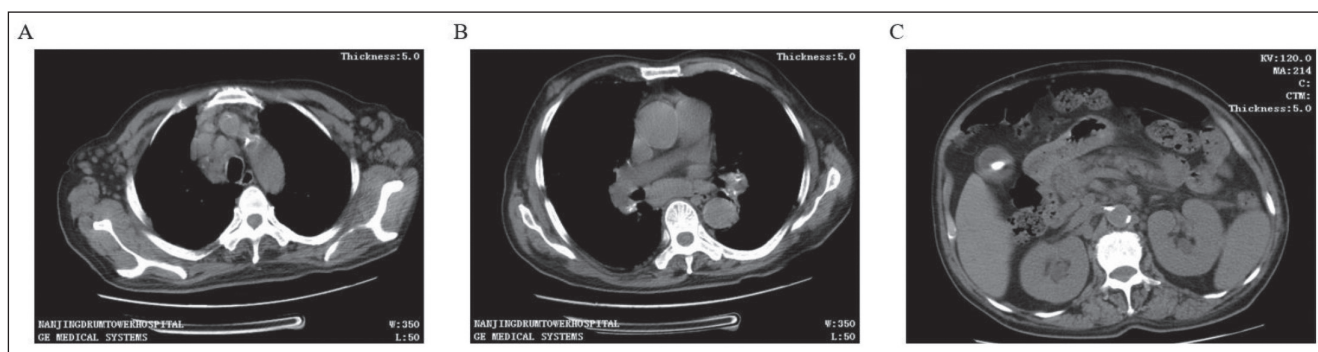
Radiological findings of the lymphadenopathy associated with IgG4-related disease. A: Chest CT revealed lymph nodes swelling in axilla. B: There were swollen lymph nodes in mediastinum, pulmonary hilum and cardiac diaphragm angle. C: The lymph nodes of retroperitoneum and abdominal cavity were also swollen.
